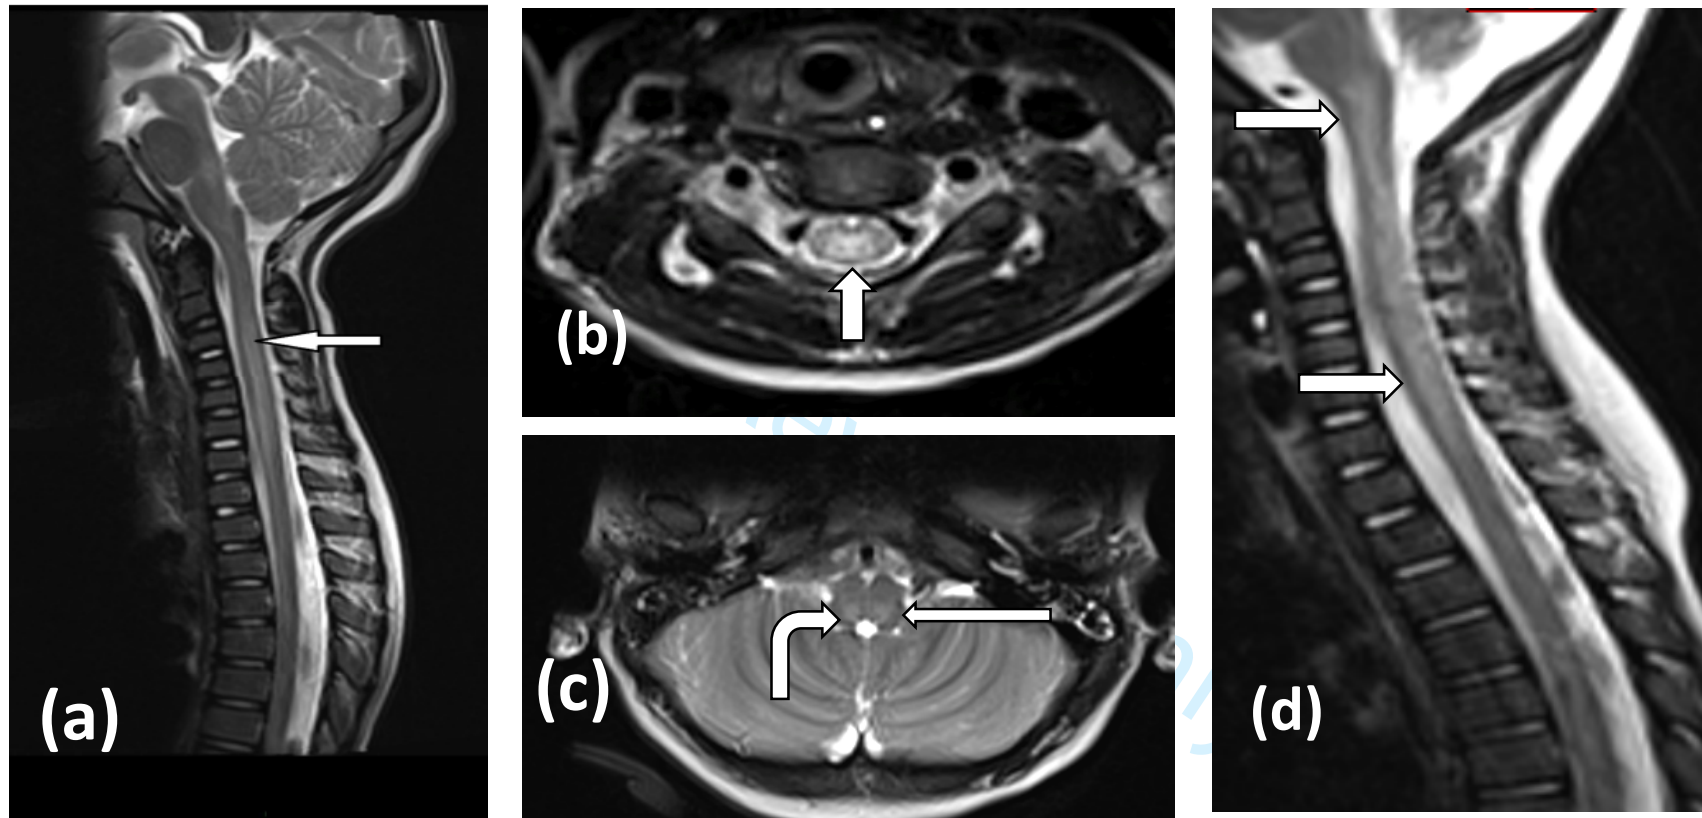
MRI spine and brainstem in AFM due to EV D68- Scotland
